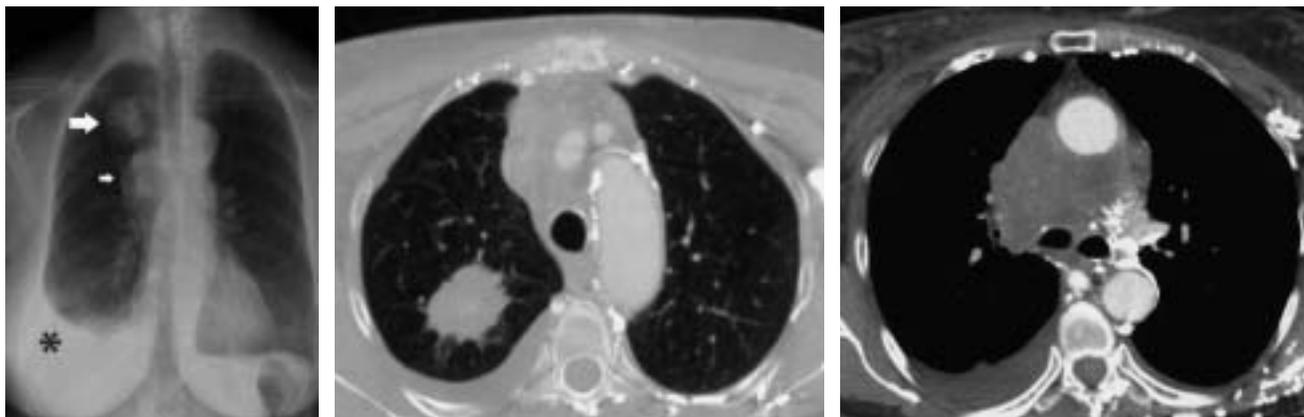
Left, Frontal chest radiograph of a 62-year-old woman with superior vena cava syndrome showing a right upper lobe nodule (large arrow) with a right hilar/mediastinal mass (small arrow) and a right transudative pleural effusion (asterisk). Middle, Contrast-enhanced computed tomogram at the level of the aortic arch revealing a right upper lobe mass confirmed by transthoracic biopsy as a non-small cell carcinoma. Right, Contrast-enhanced computed tomogram showing a right mediastinal and hilar mass that occludes the superior vena cava. Note the mediastinal and left chest wall venous collaterals and edema of the subcutaneous fat resulting from superior vena cava occlusion.
